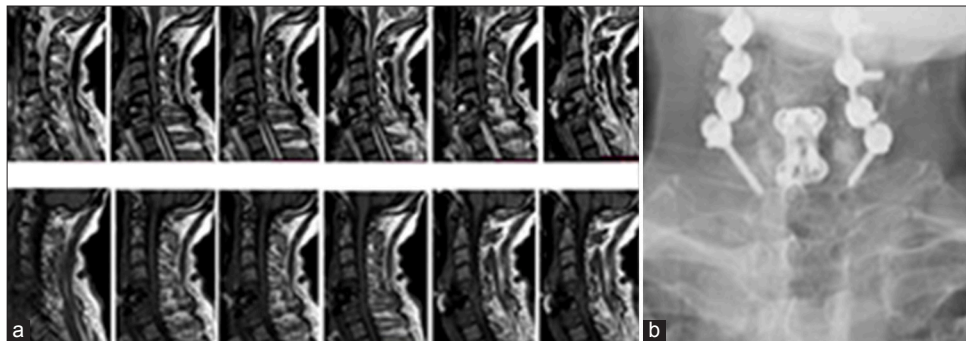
(a) Sagittal sections of the patient's cervical spinal magnetic resonance imaging showing signs of osteomyelitis at the surgical site, along with cervical spinal canal stenosis at the same levels. (b) Stabilization was achieved with posterior bilateral C7 pedicle screws and C4–C6 lateral mass screws.
